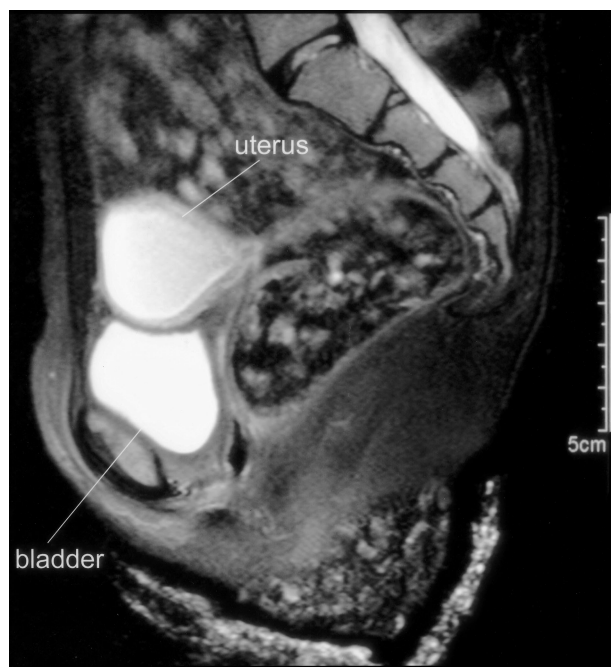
Pelvic magnetic resonance image demonstrating a markedly thinned and dilated uterine myometrium and recurrent hematometra.
